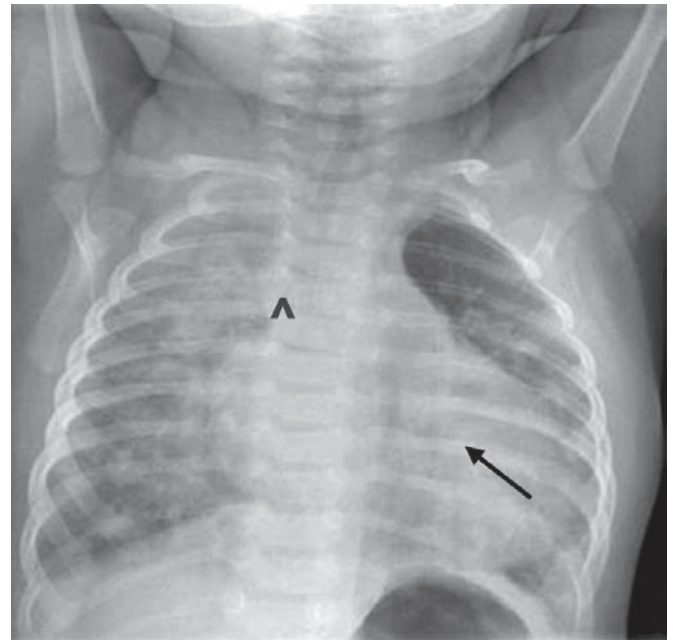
Chest radiograph showing marked cardiomegaly with left ventricular enlargement (downward pointing apex, arrow), left atrial enlargement resulting in carinal splaying and areas of atelectasis interspersed with hyperinflation, and pulmonary oedema in a patient with a large PDA. Atelectasis is due to a large left atrium compressing the airways
